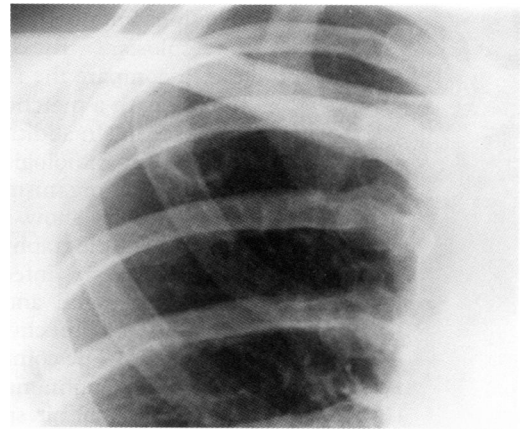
Chest radiograph of a patient with *M kansasii* infection showing a solitary thin walled cavity with no surrounding consolidation in the right upper lobe.
